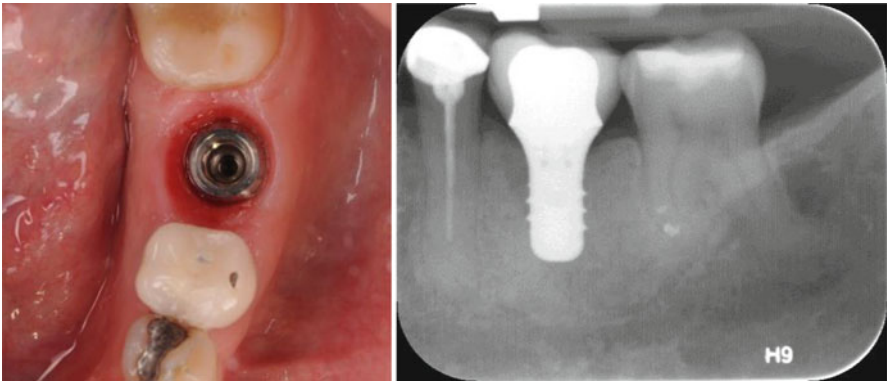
Photo of a nicely healed implant with good gingival contour. The radiograph shows no space between the abutment and the implant body
